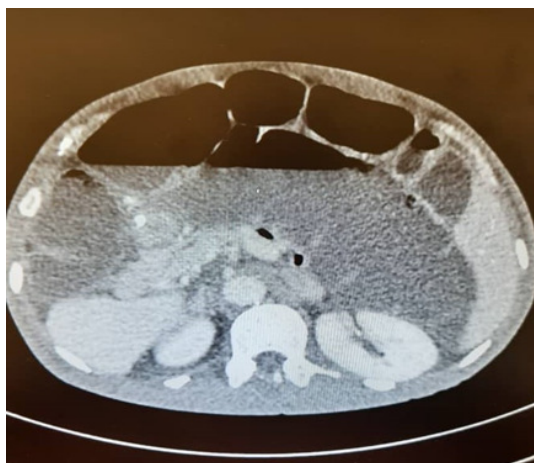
Abdominal computerized tomography (CT) demonstrated dilatation of the large and small intestine with a possible transition zone at the splenic flexure area.
